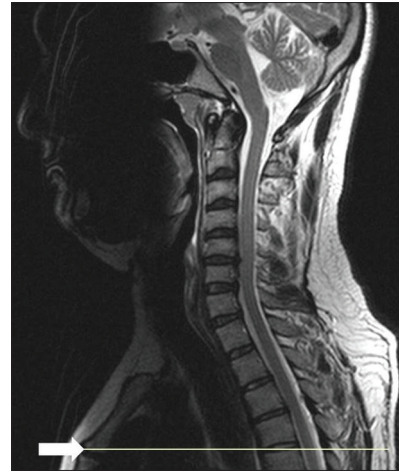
T2-weighted mid-sagittal image of the cervicodorsal spine with horizontal reference line to evaluate the vertebral level of sternal angle (white arrow)
